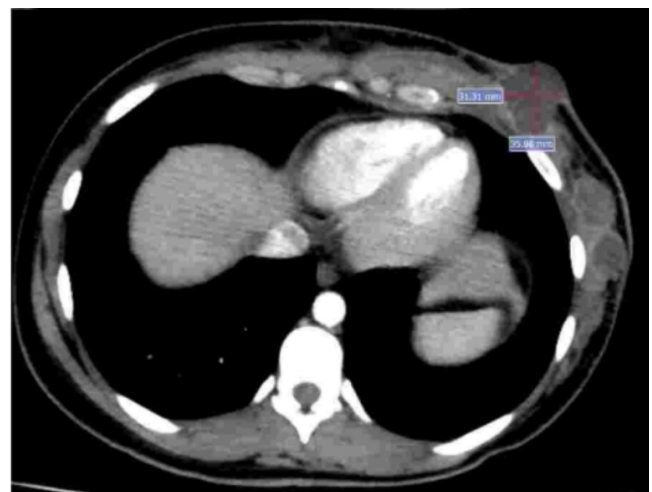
Chest computed tomography demonstrating local recurrence.
